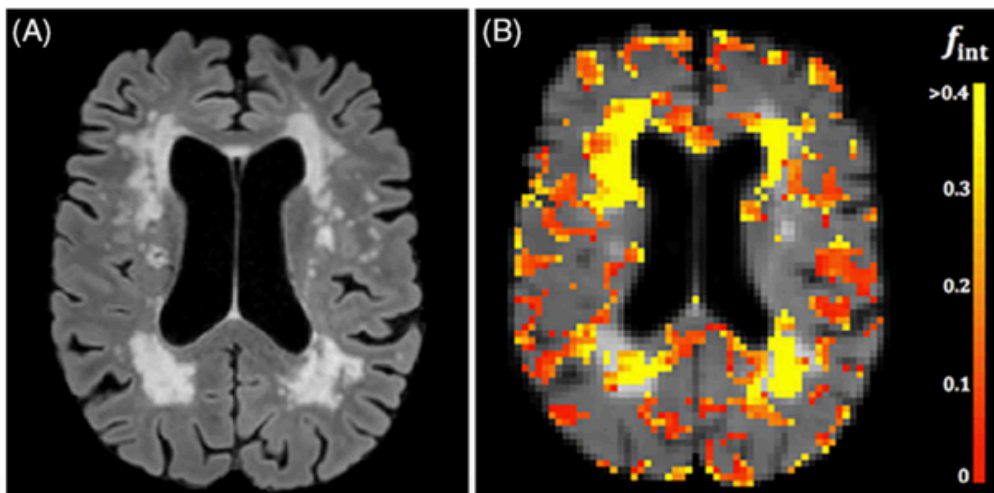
High values of intermediate diffusion volume fractions (color-coded map in b) strongly colocalize with WMH (FLAIR image in a). Images of a male, a 79-year-old patient with cerebral small vessel disease [56].
